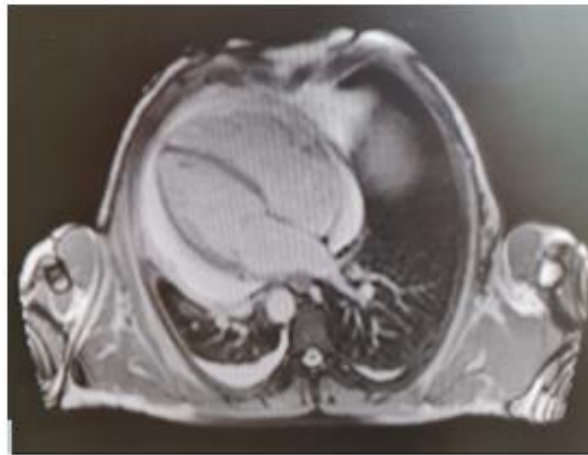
MRI revealed ubiquitous pericardial effusion of moderate-severe degree with a maximum detachment of 3 cm without signs of haemodynamic compromise.
